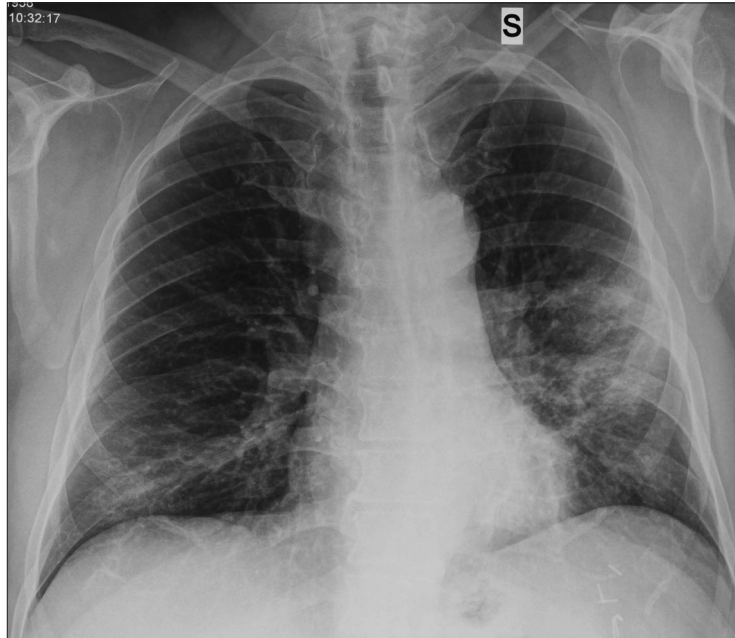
Chest X-ray at the admission: bilateral patchy opacities in both lower lobes, predominantly in the left lung.
